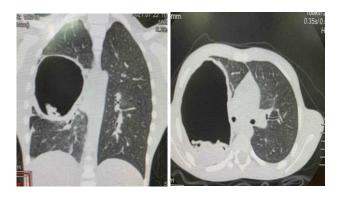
Preoperative chest CT – imaging data of pulmonary hydatid cyst complicated by rupture in the bronchus.
